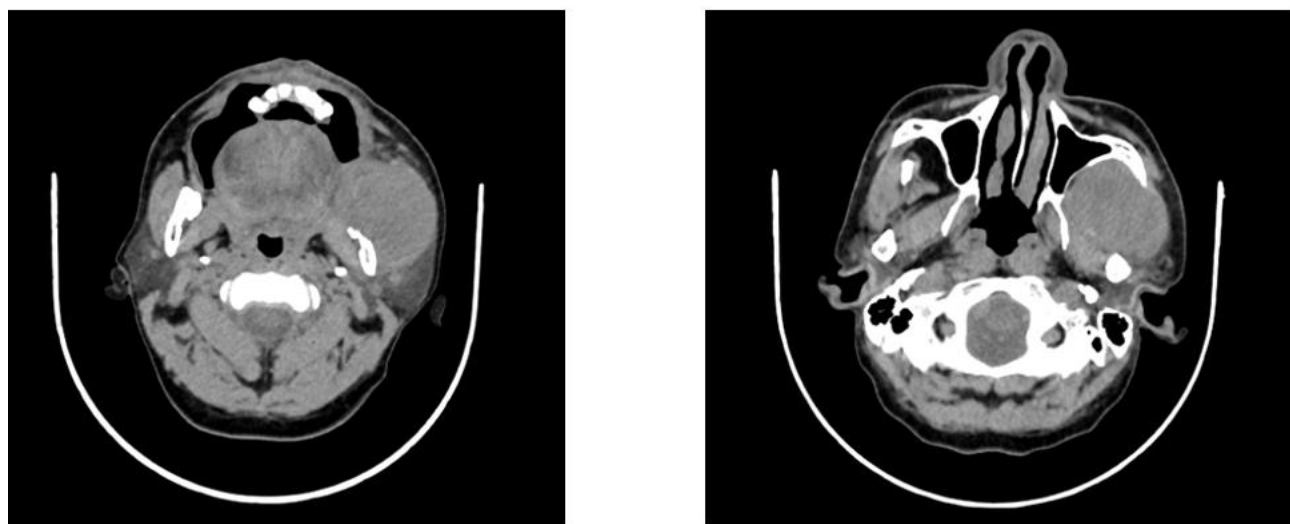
Patient radiographic evaluation.
